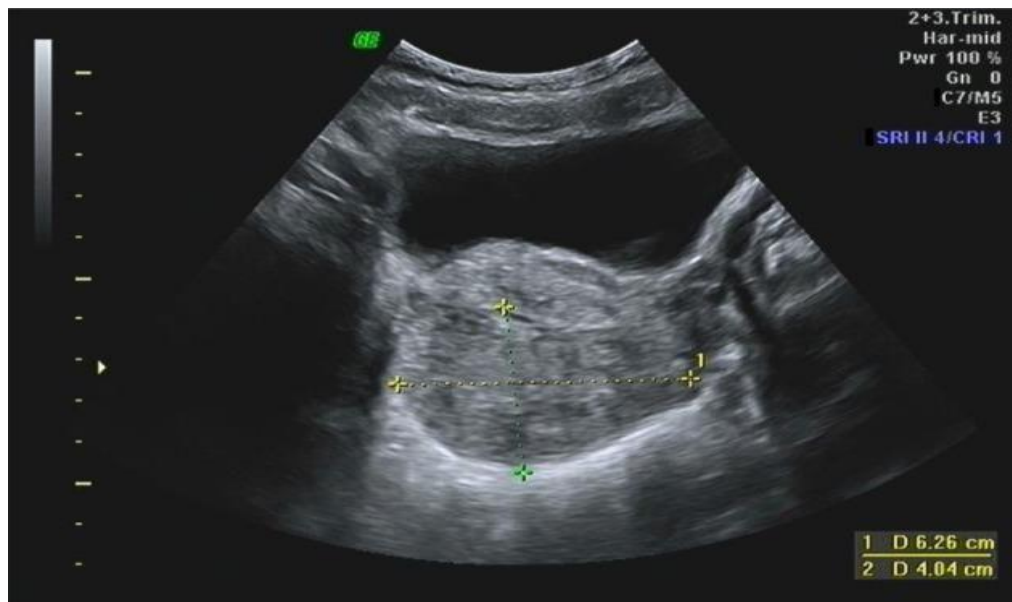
Transvaginal ultrasound in a 64-year-old woman with pelvic mass.
